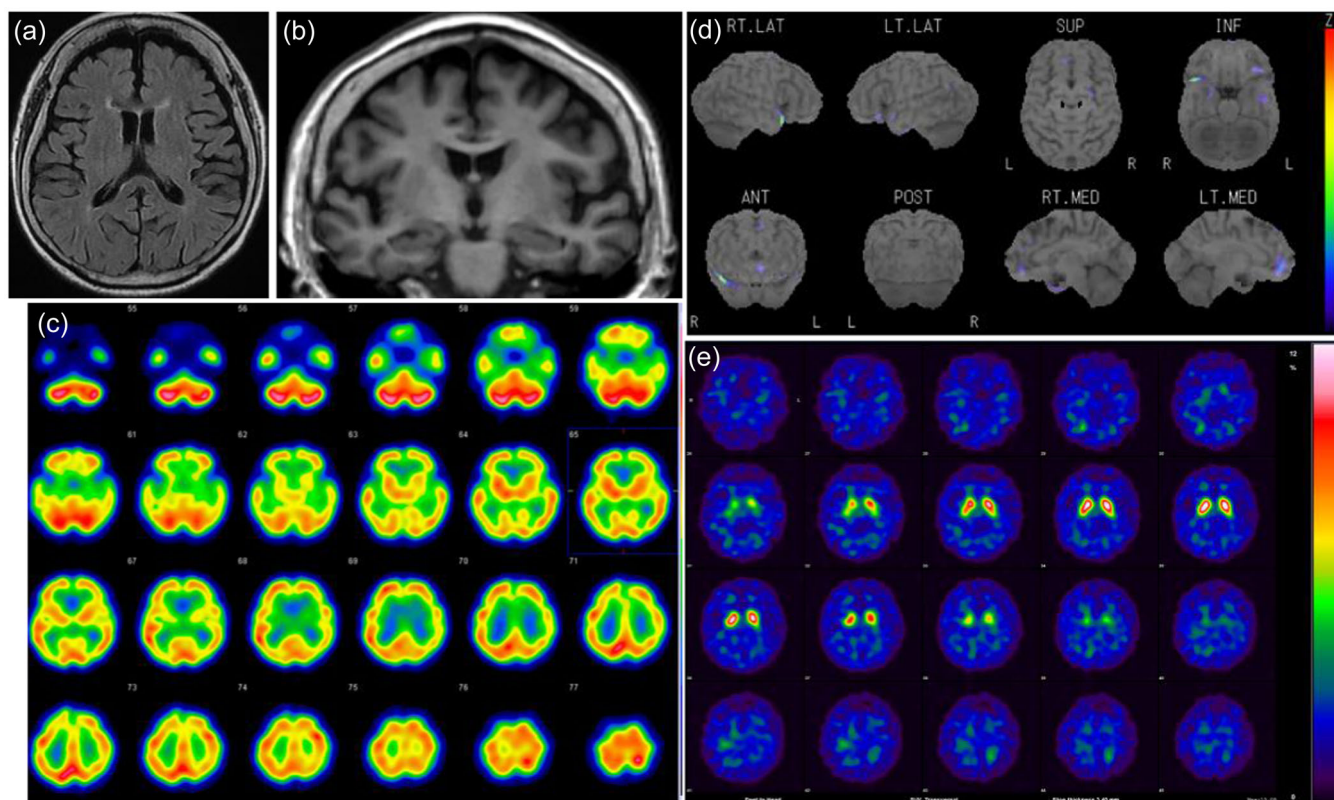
(a) Brain magnetic resonance (MR) FLAIR image. Mild atrophy was observed in the medial frontal lobes, and a small subcortical infarction was noted in the right periventricular white matter. (b) T1-weighted MR image. Atrophy was not evident in the medial temporal lobe. (c) Iodine-123-labeled *N*-isopropyl-*p*-iodo-amphetamine single-photon emission computed tomography (SPECT). Hypoperfusion was observed in the right frontal, left temporal, and occipital lobes. (d) Statistical images by three-dimensional stereotactic surface projection. The reference region is the whole brain. There were no significant hypoperfusion areas of note. (e) ^{123}I -*N*-fluoropropyl-2b-carbomethoxy-3b-(4-iodophenyl) nortropane SPECT. It showed no reduced striatal uptake. The right and left striatal-specific binding ratios were 6.19 and 5.87, respectively.
